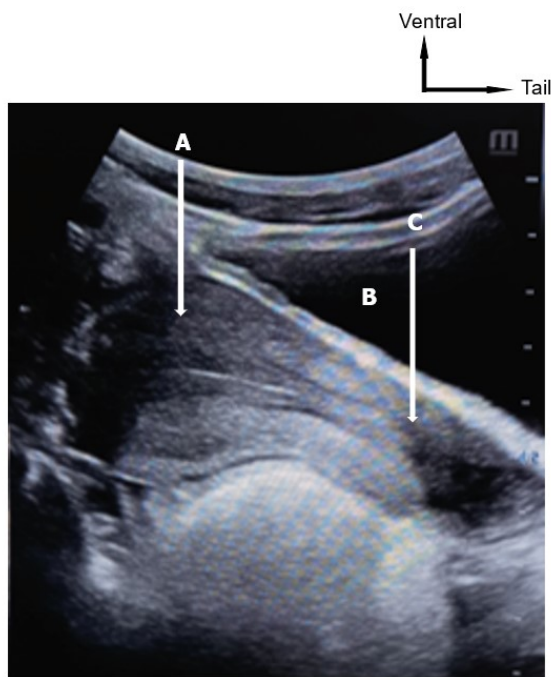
Suprapubic ultrasound sagittal section showing an anteverted and retroflexed uterus.
